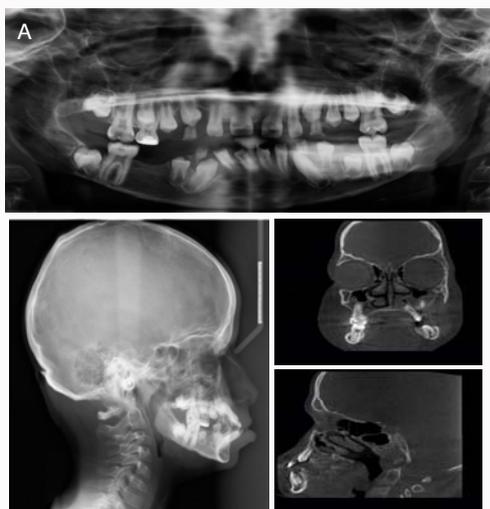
Pre-treatment radiographs of patient demonstrating unusual findings: (A) Panoramic radiograph showing close proximity of the apices of both lower first molars with the inferior border of the mandible. Loss of cortical definition was noted and the mandible appeared hypoplastic with a decrease in both the vertical dimension of the body of the mandible and the horizontal dimension of the ramus of the mandible. The mandibular right 2nd premolar was congenitally missing. (B) Lateral cephalometric radiograph showing evidence of mid facial and gonial angle deficiency together with reduced vertical dimensions of the mandible. (C and D) Coronal and sagittal cone beam CT images showing bilateral increase in the thickness of the posterior lateral wall of the right and left maxillary sinuses which gave the appearance of a minified right and left maxillary sinus and there was also an increased in thickness of the soft palate.
